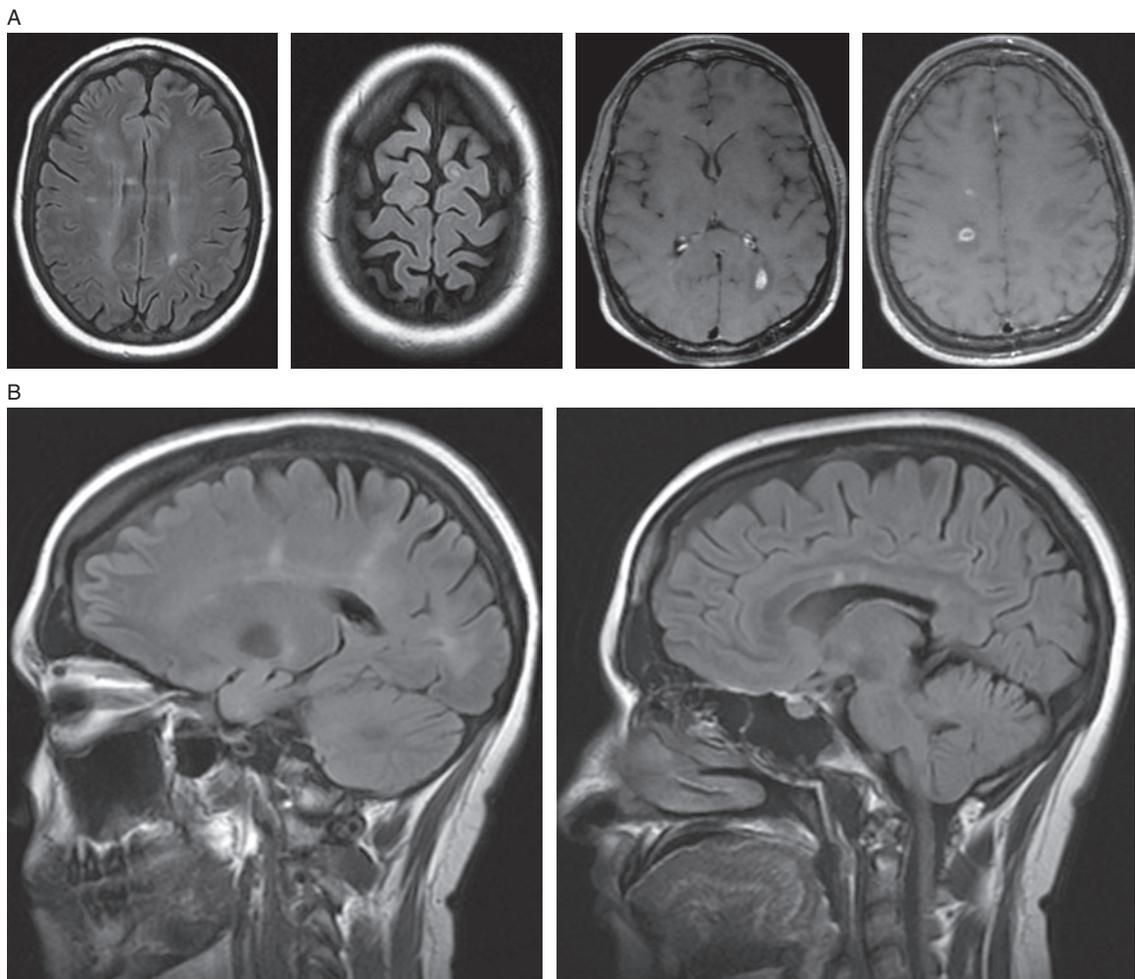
A) Axial MRI brain showing typical FLAIR periventricular, juxtacortical and T1 gadolinium-enhancing lesions. B) Sagittal MRI brain FLAIR sequence showing typical "Dawson's fingers" and corpus callosum MS lesions.
